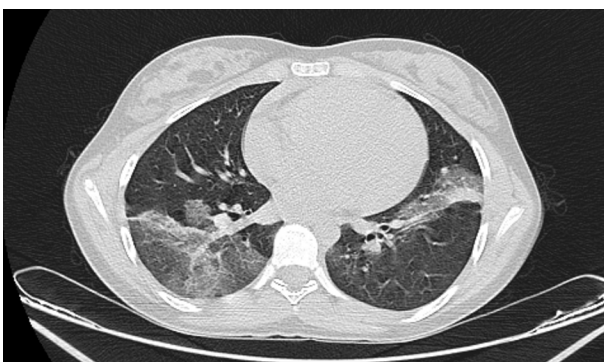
The view of computed tomography on admission. It reveals ground-glass opacities and interlobular septal thickenings in the bilateral lung parenchyma (crazy-paving pattern), peribronchial thickenings, and occasional discoid atelectasis.
